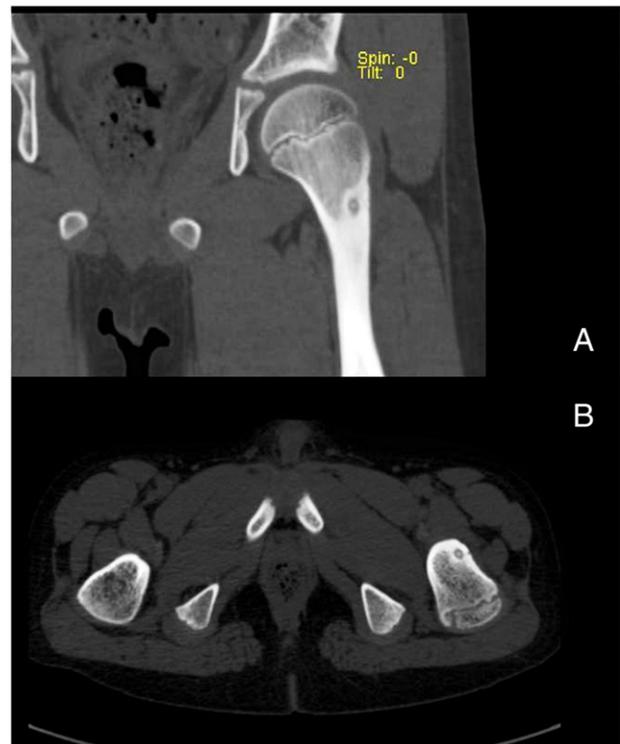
Coronal reconstruction computed tomography showing an osteoid osteoma nidus in the neck of the left femur with calcification and prominent sclerosis (A). Pelvic computed tomography showing a subcortical osteoid osteoma in the neck of the left femur surrounded by sclerosis (B).
